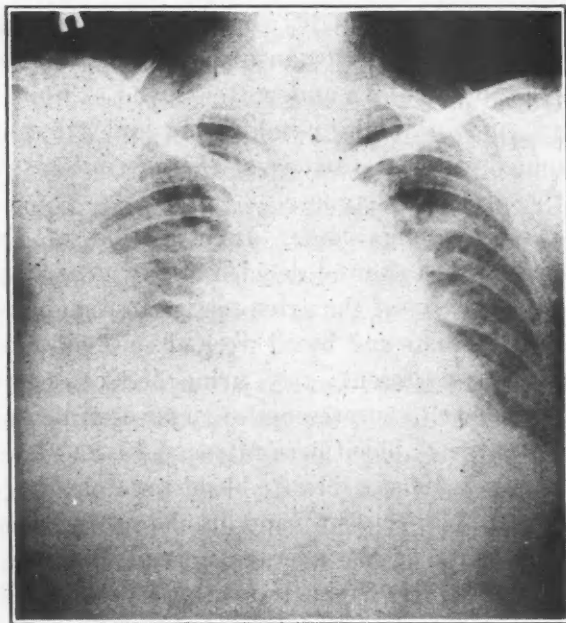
Miss B. X-ray chest showing metastases in right lower chest.
